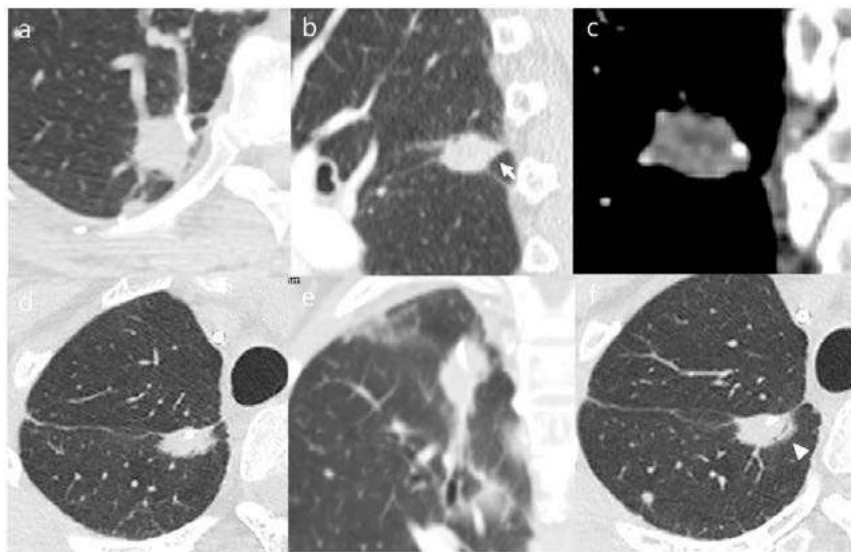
Representative CT image of staple line granuloma (a-c) and tumor recurrence (d-f).
